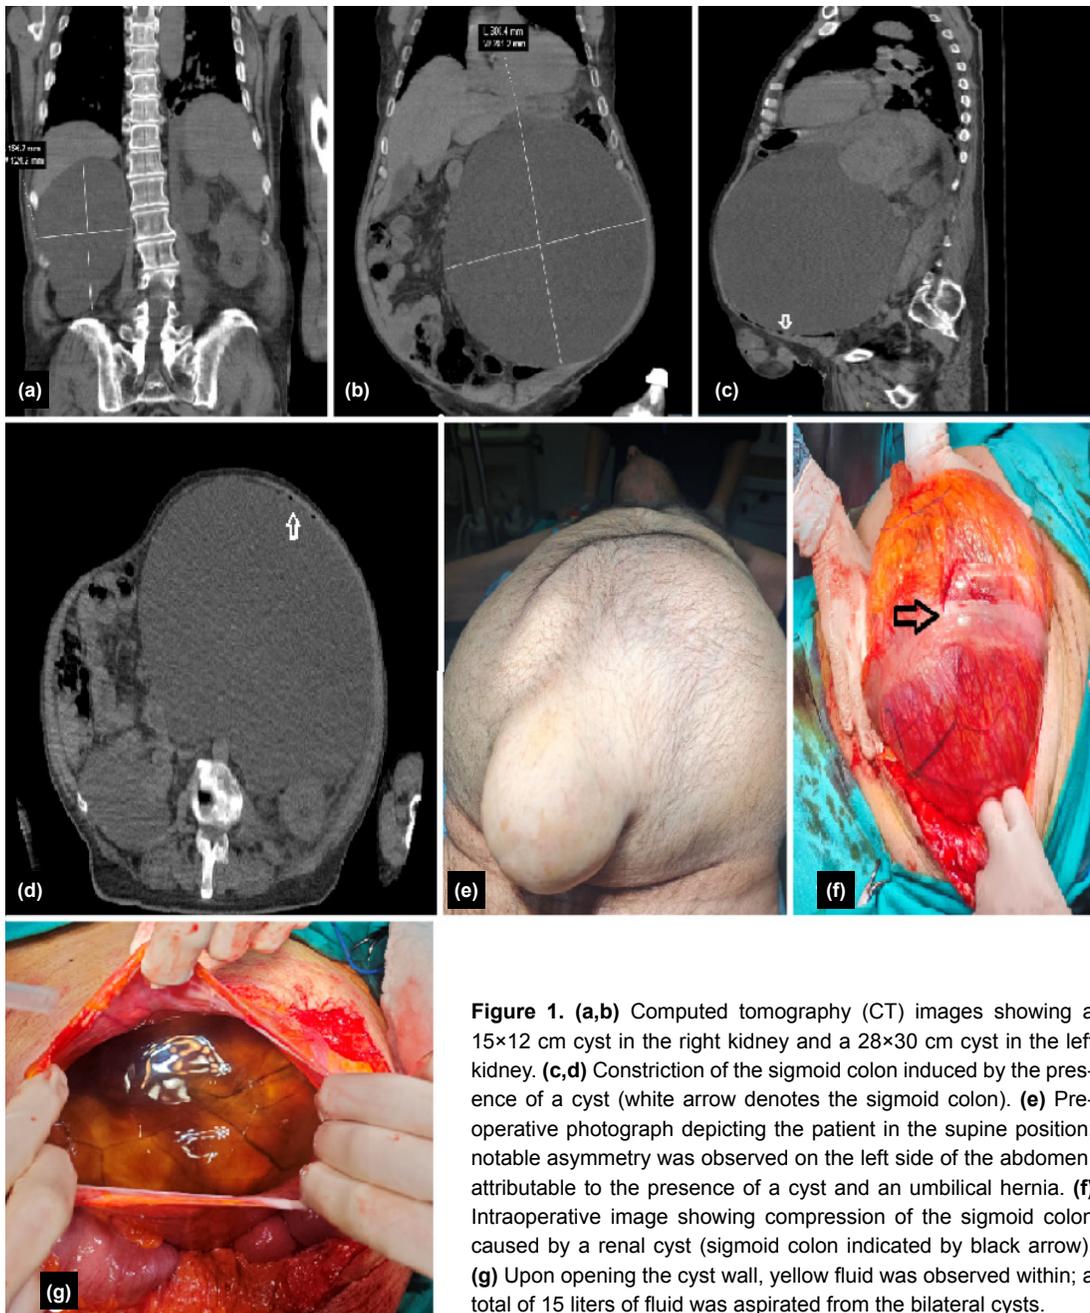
(a,b) Computed tomography (CT) images showing a 15×12 cm cyst in the right kidney and a 28×30 cm cyst in the left kidney. (c,d) Constriction of the sigmoid colon induced by the presence of a cyst (white arrow denotes the sigmoid colon). (e) Pre-operative photograph depicting the patient in the supine position; notable asymmetry was observed on the left side of the abdomen, attributable to the presence of a cyst and an umbilical hernia. (f) Intraoperative image showing compression of the sigmoid colon caused by a renal cyst (sigmoid colon indicated by black arrow). (g) Upon opening the cyst wall, yellow fluid was observed within; a total of 15 liters of fluid was aspirated from the bilateral cysts.
